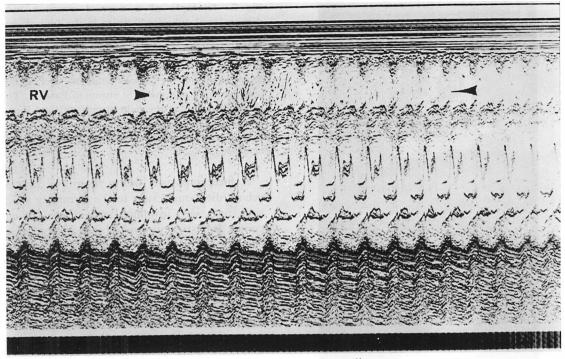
Example of a normal M-mode contrast echocardiogram.
